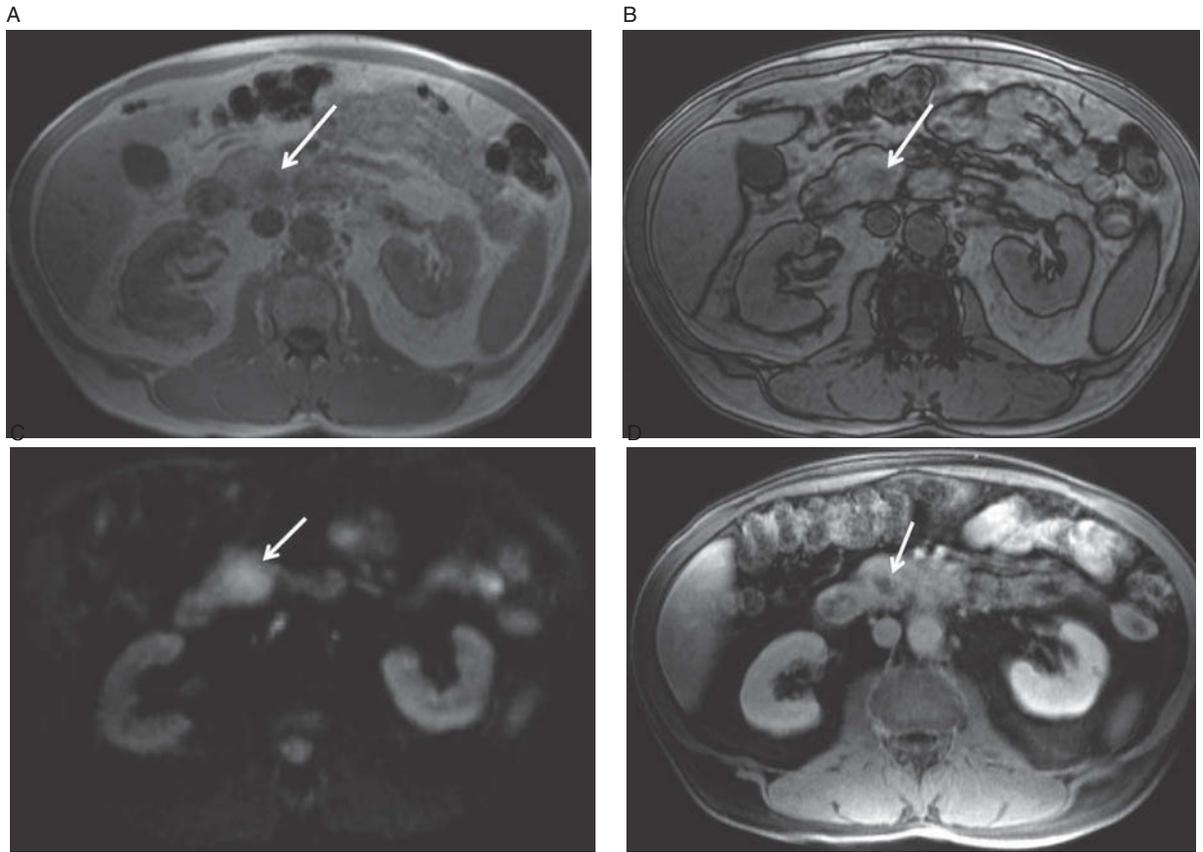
Pancreatic adenocarcinoma. Axial in-phase and out-of-phase images (A, B) demonstrate the normal bright T1 signal of the pancreas with a focal, rounded area of low signal (arrows). This should always raise your suspicion for pancreatic adenocarcinoma. Image (C) is a b-500 DWI demonstrating restricted diffusion of this mass. I include this image not because it is necessary or necessarily typical, but because it is gorgeous. Axial, T1-weighted, fat-saturated post-contrast image (D) shows the normal enhancing pancreatic parenchyma with the focal hypoenhancing mass (arrow).
